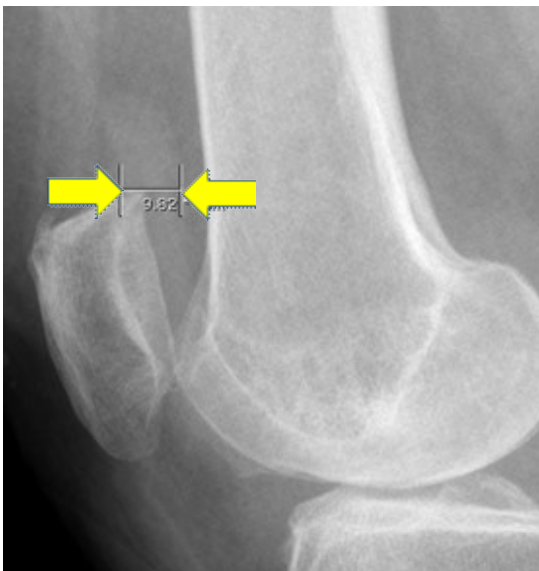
Knee joint effusion on weight-bearing lateral radiograph (arrow).
